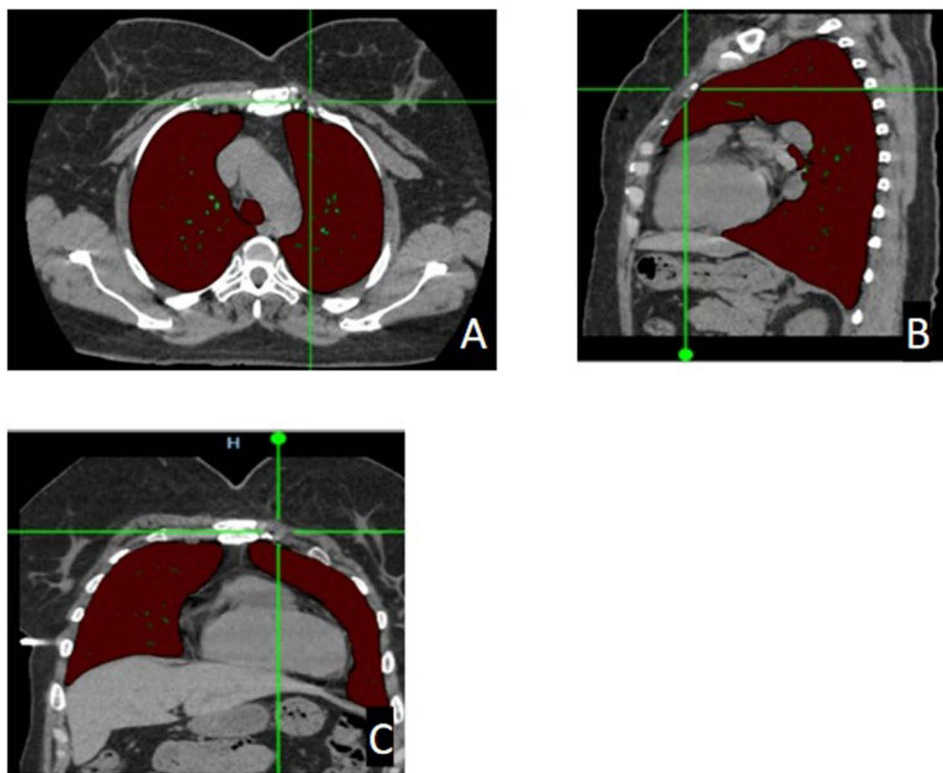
Chest Computed Tomography (16 October 2024) revealed: "In bone window settings, bony outgrowths were identified in the projection of the cartilaginous portions of the left 2nd and 3rd ribs". (A) Axial slice. (B) Sagittal slice. (C) Coronal slice.
